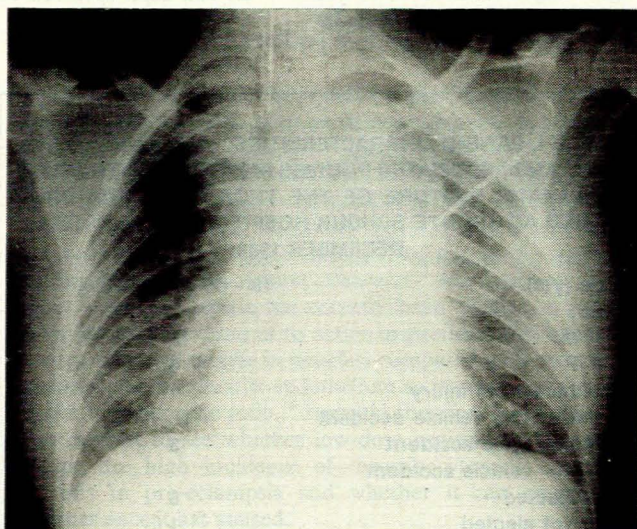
Chest radiograph of a patient with traumatic rupture of the descending thoracic aorta. The common radiographic signs — a wide mediastinum, left apical pleural cap, loss of aortic knob and obliteration of the aortopulmonary window — are easily seen.
